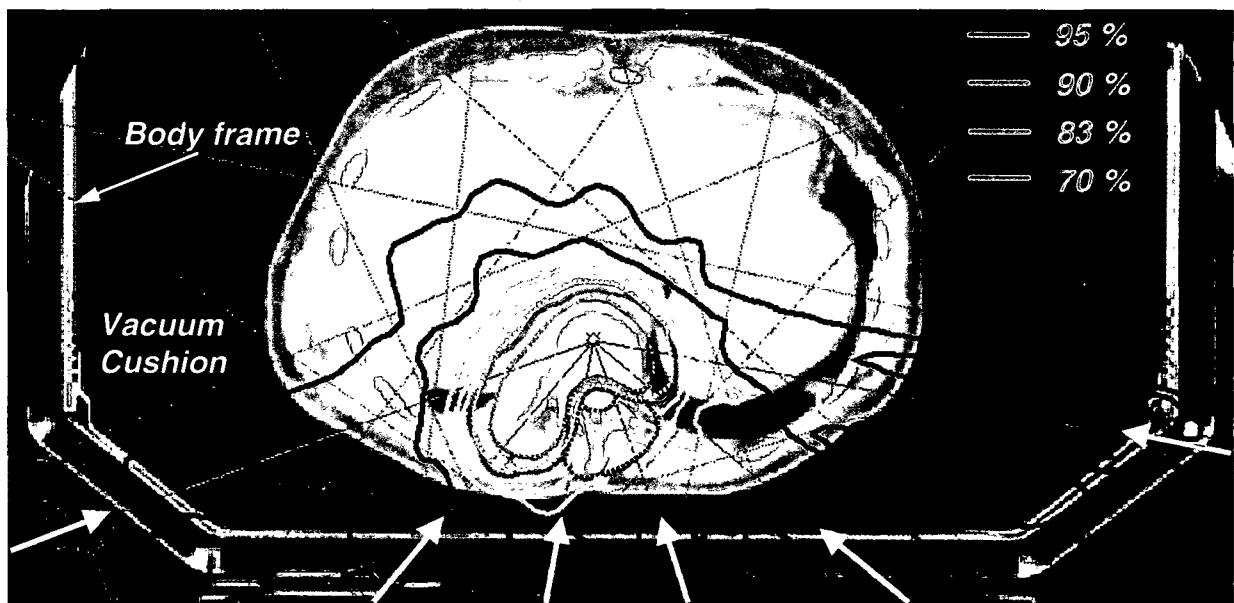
Dose distribution in an axial CT slice, resulting from overall 69 segments in six beam incidence directions (orange arrows). In order to allow reduced safety margins, the patient was positioned in a body frame and immobilized by a vacuum mattress, adapted to the patient's outline.
